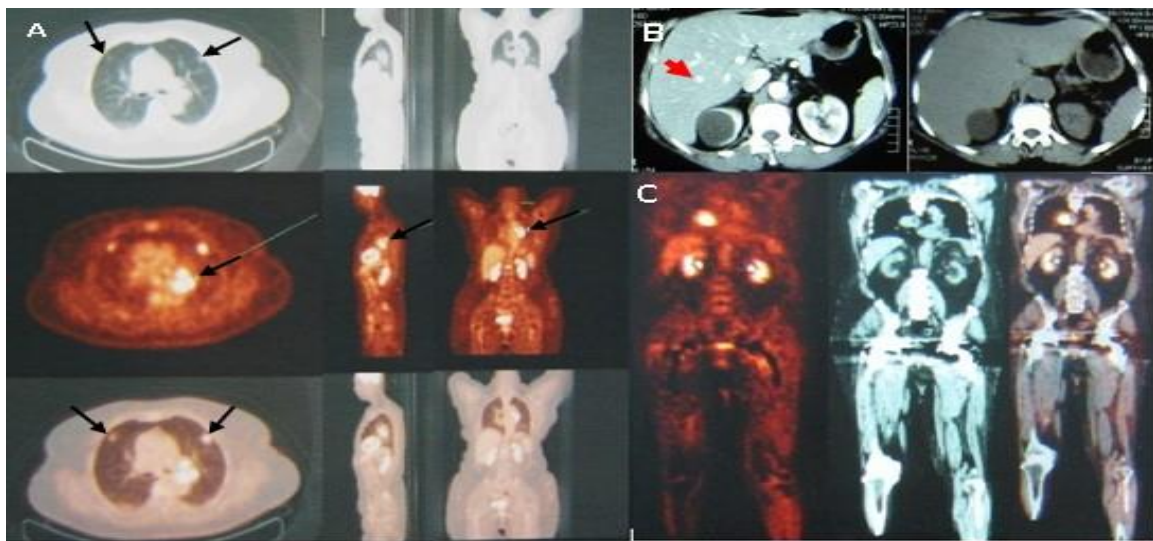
A- Base-line 60 year old female with rectal carcinoma, ^{18}F -FDG PET/CT scan A- Transaxial, sagittal and coronal (from LT to RT) images show FDG uptake in multiple bilateral lung metastases (black arrows). B- Contrast enhanced CT shows equivocal liver lesion as hyperdense nodule in segment VIII of liver in arterial phase (LT, red arrow), while venous phase (RT) is free. C- Follow-up PET/CT after 6 months confirmed lung metastases while hepatic lesion shows no FDG uptake and proved to be focal nodular hyperplasia.
